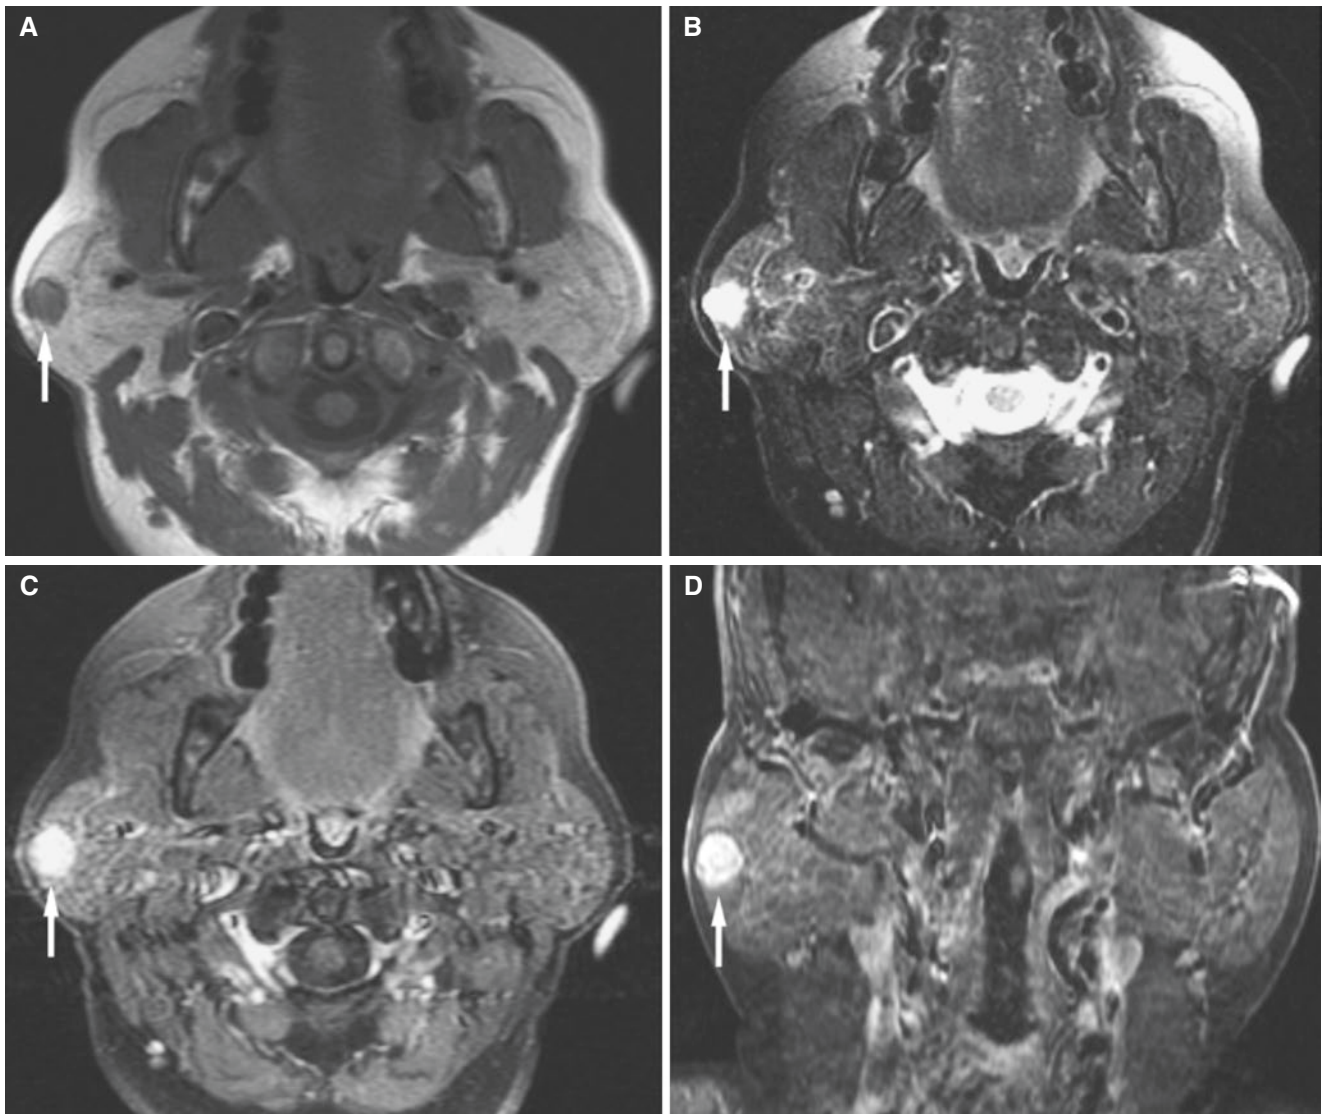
Parotid pleomorphic adenoma, superficial lobe, small; 62-year-old female with lump in the right parotid gland. (A) Axial T1-weighted MRI shows rather well-defined small low-signal mass superficial in the right parotid (*arrow*). (B) Axial T2-weighted
